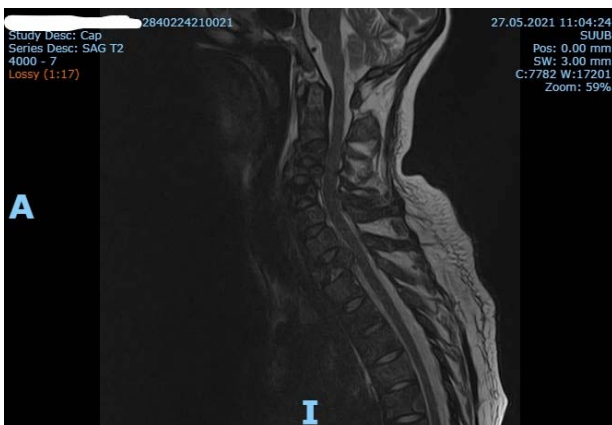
MRI image showing malignant-looking layered cervical vertebral compressions at the level of C3-4-5, tumor mass causing intracanal compression at T1 level
